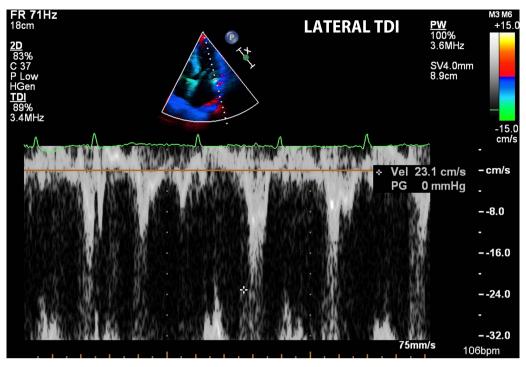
Tissue Doppler imaging showing normal lateral annular velocities.
